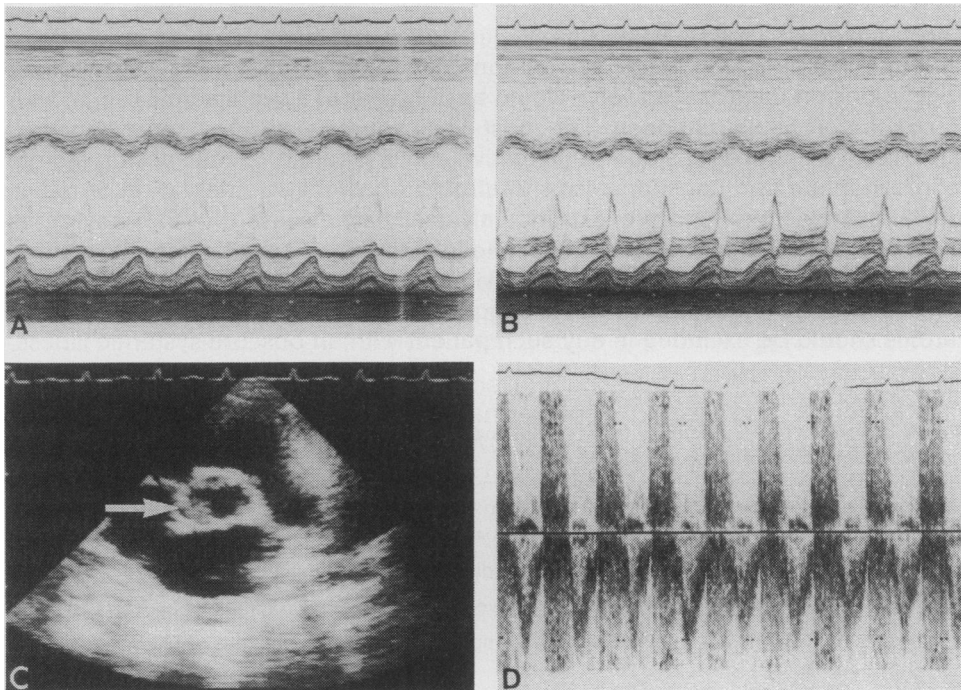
Echocardiographic examination showing (a) a dilated left ventricle with impaired systolic function, (b) marked premature closure of the mitral valve, (c) a vegetation on the non-coronary cusp of the aortic valve (arrowed) and (d) marked diastolic and lesser systolic turbulence in the left ventricular outflow tract.
